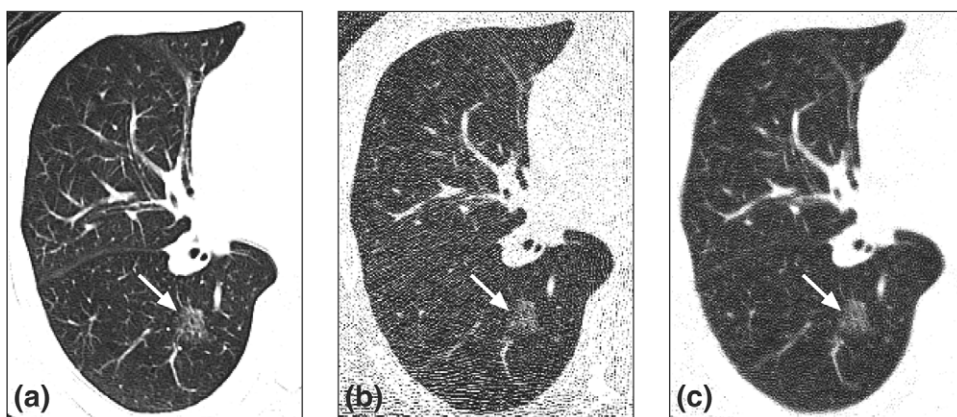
Adaptive filtering to reduce noise artifacts for low-dose imaging. The scan of the right lung of this patient shows a nonsolid pulmonary nodule (arrow). (a) Image reconstructed from x-ray projection data acquired using a system configuration of 120 kVp, 200 mAs, 0.5 s gantry speed (100 mAs),  $4 \times 2.5$  mm detector collimation, and a helical pitch ratio of 0.75:1 using a GE Lightspeed Plus (GE Medical Systems, Milwaukee, Wisconsin). (b) The same anatomy was scanned at much lower dose; the image was reconstructed from x-ray projection data acquired using a system configuration of 120 kVp, 10 mA, 0.5 s gantry speed (5 mAs),  $4 \times 1.5$  mm detector collimation, and a helical pitch ratio of 1.5:1. (c) The same x-ray projection data used to generate the image shown in (b) was reconstructed using a reconstruction algorithm incorporating adaptive filtering techniques. In all three images the nodule is visible; however, the image shown in (c), which was reconstructed using adaptive filtering techniques, contains less noise artifact when compared with the image in (b), at a slight reduction in the spatial resolution when compared with the image in (a). (Courtesy of Akifumi Fujita, MD, Showa University, Fujigaoka Hospital.)
